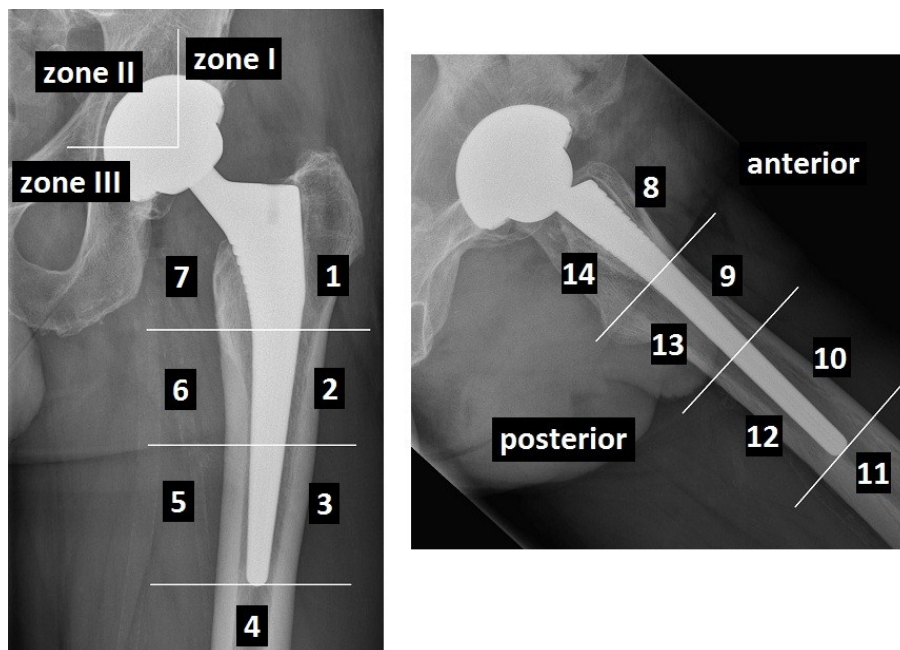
a/b: Acetabular DeLee-Charnley zones I-III and femoral Gruen zones 1-7 on an anteroposterior hip radiograph and Gruen zones 8-14 on an axial hip radiograph
